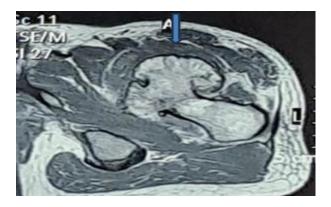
MRI scan of left hip with bony lesion over the lesser trochanter and cartilage thickness of 2.4 mm.
